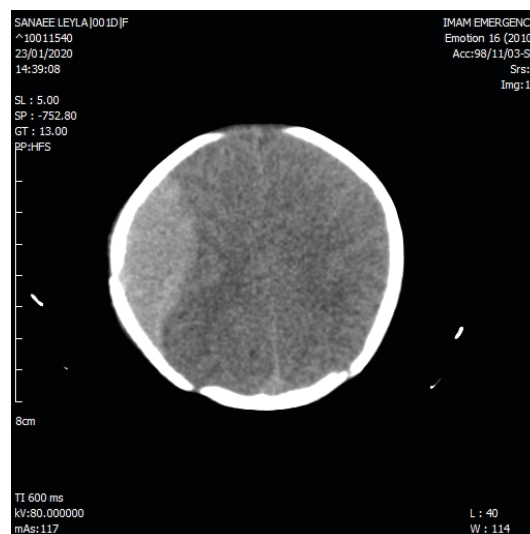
An acute epidural hematoma on pre-operation CT-scan.
